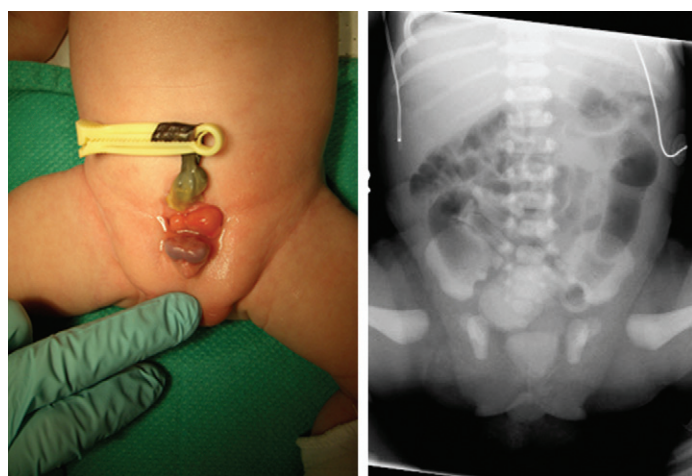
Bladder exstrophy, accompanied by epispadias. Radiograph demonstrates absence of the symphysis pubis, and external rotation of the pelvic girdle. (Clinical photo courtesy of Jonathan Ross, M.D.; radiologic image courtesy of Raj Paspulati, M.D.)
